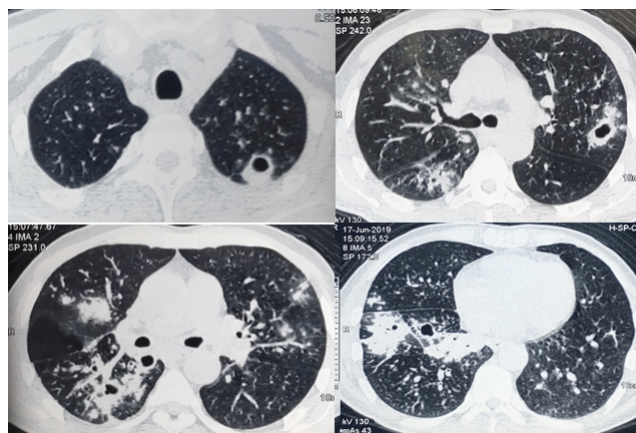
HRCT chest at presentation: showing multiple thick-walled cavities with pericavitory consolidation in RUL, RLL, LUL and LLL with parenchymal infiltrations and tree in bud appearance
